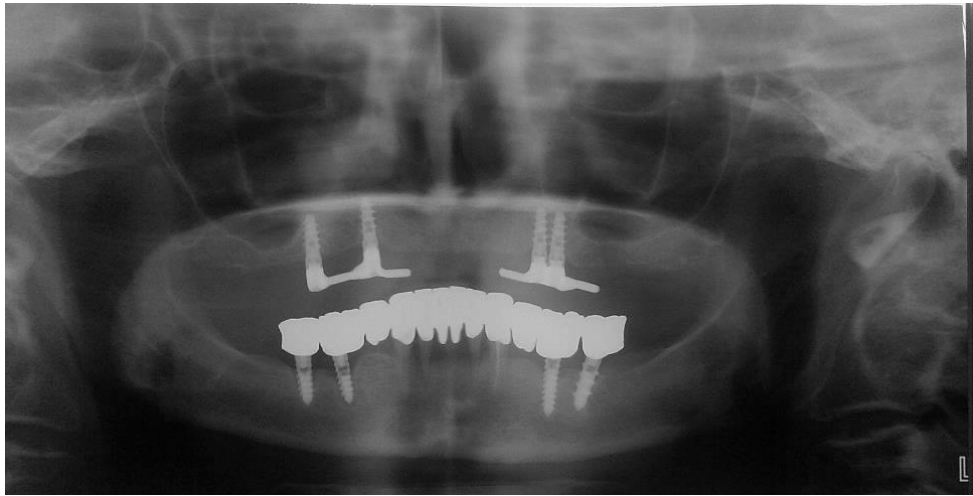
panoramic X-ray showing inferior rehabilitation on implants and natural teeth.*
